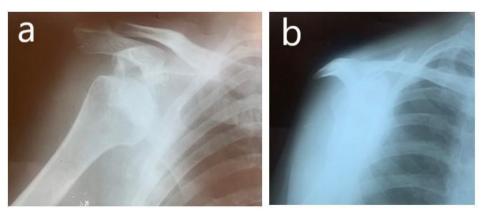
X-rays views in AP (a) and Lateral view (b) of patient.
